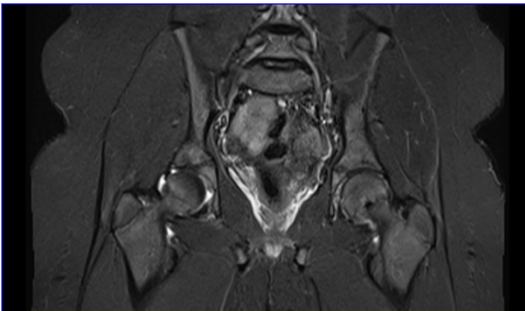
STIR coronal MRI of a male child shows right early slipped femoral capital Epiphysis
